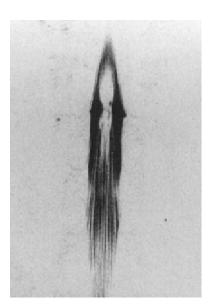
MRI of the conus medullaris and the cauda equina depicting an area of infarct on the right side extending towards the center.
